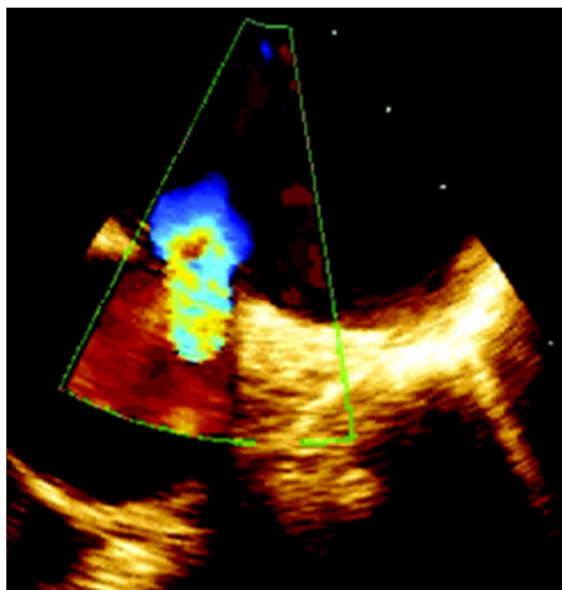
Patent ductus arteriosus (PDA) in Transesophageal echocardiography
